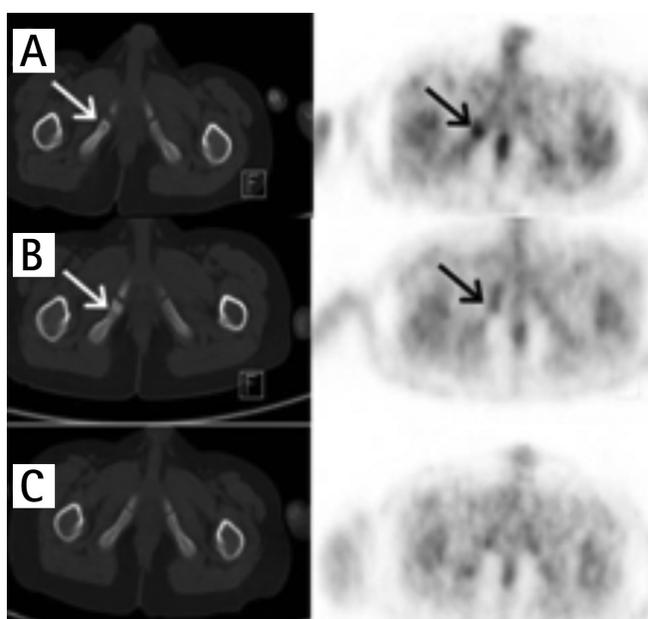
A) Axial positron emission tomography/computed tomography images of the pelvis in the bone window setting showed radiolucency and enlargement at the right ischium and increased focal fluorodeoxyglucose uptake at that area. B) Sclerosis at the same localization and decreased fluorodeoxyglucose uptake four months after therapy were seen. C) After 12 months of therapy no abnormal findings were detected on positron emission tomography/computed tomography scan (arrows)
